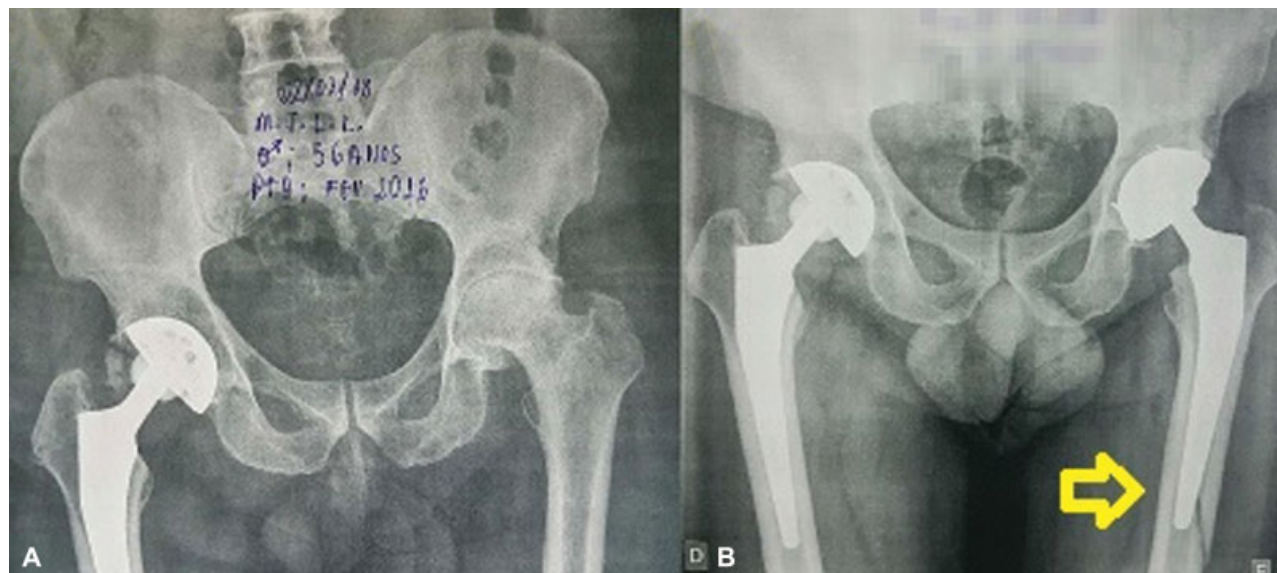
Preoperative anteroposterior pelvic radiograph of a 56-year-old male with left-sided ONFH (A) and postoperative cemented DMC with stable Vancouver-type-B1 periprosthetic fracture of the femur (B). The fractures were conservatively and successfully treated.
